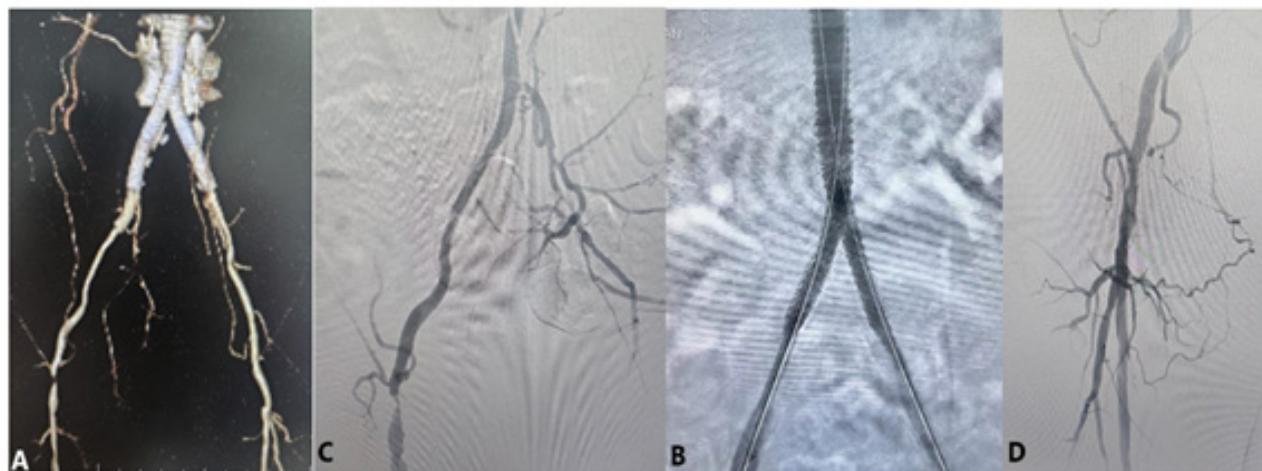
Male patient presented 6 months post-CERAB with diminish right femoral pulse & short distance claudication, computed tomography angio showed tight common femoral stenosis (A, B), diagnostic angio showed patient CERAB stent-graft (C), the lesion was treated with balloon angioplasty and DCB (D) with palpable pedal pulse at the end of the procedure.
